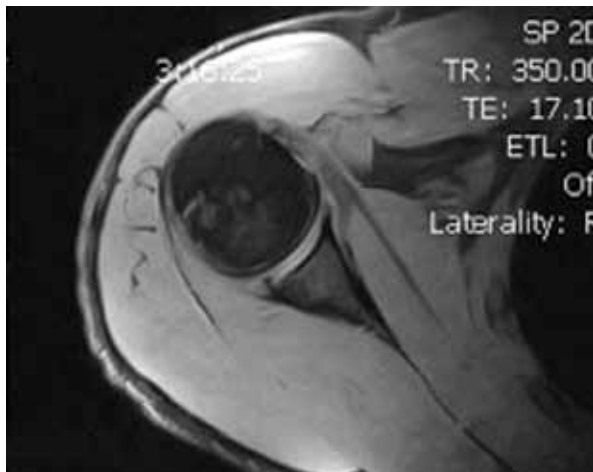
Preoperative magnetic resonance imaging shows early chondral wear on humeral head with minor rotator cuff tendonitis.
